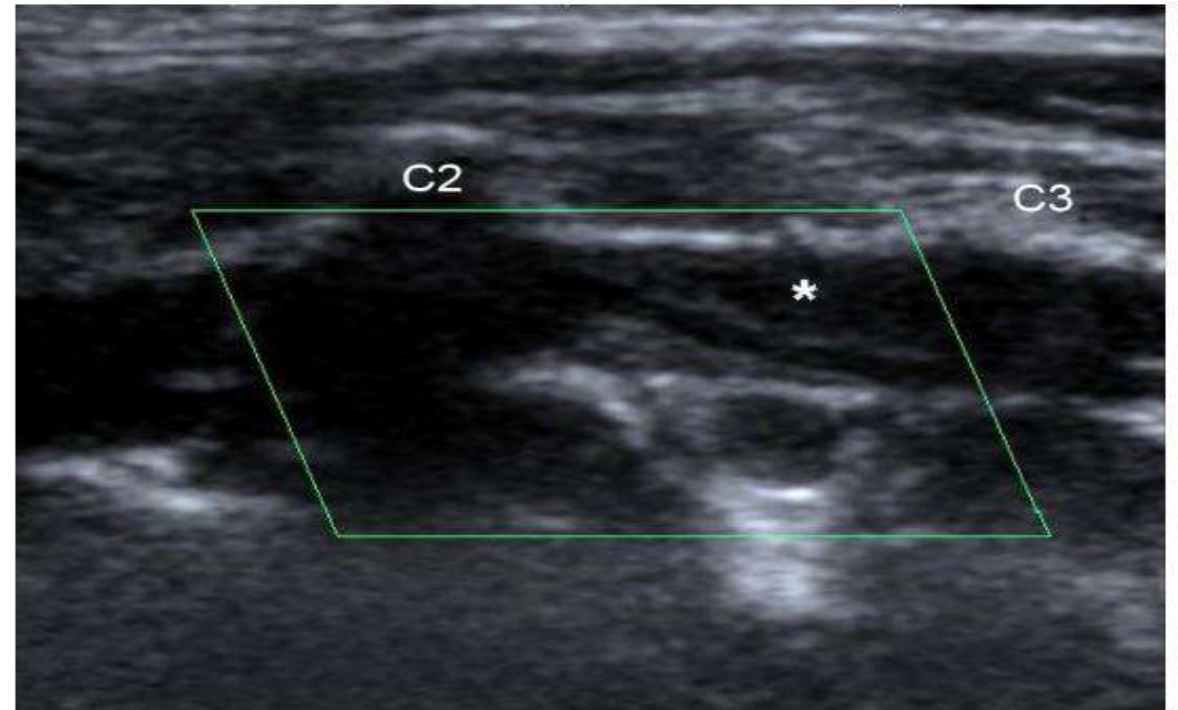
Duplex ultrasound (B-mode) shows narrowing of left intervertebral VA. The asterisk indicates the false lumen caused by intramural hematoma.
